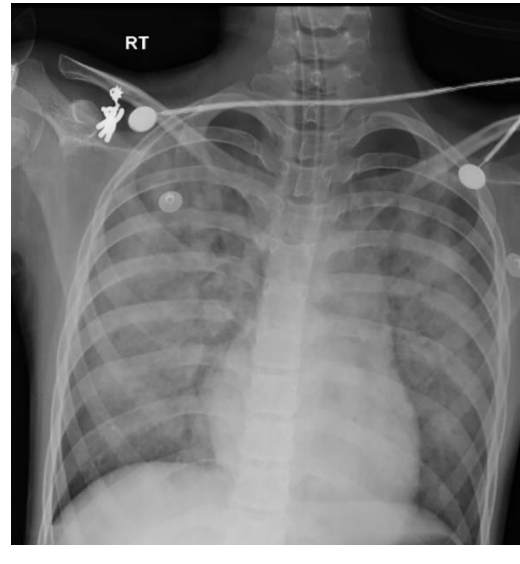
Chest X-ray shows Inhomogeneous opacifications in both lungs
